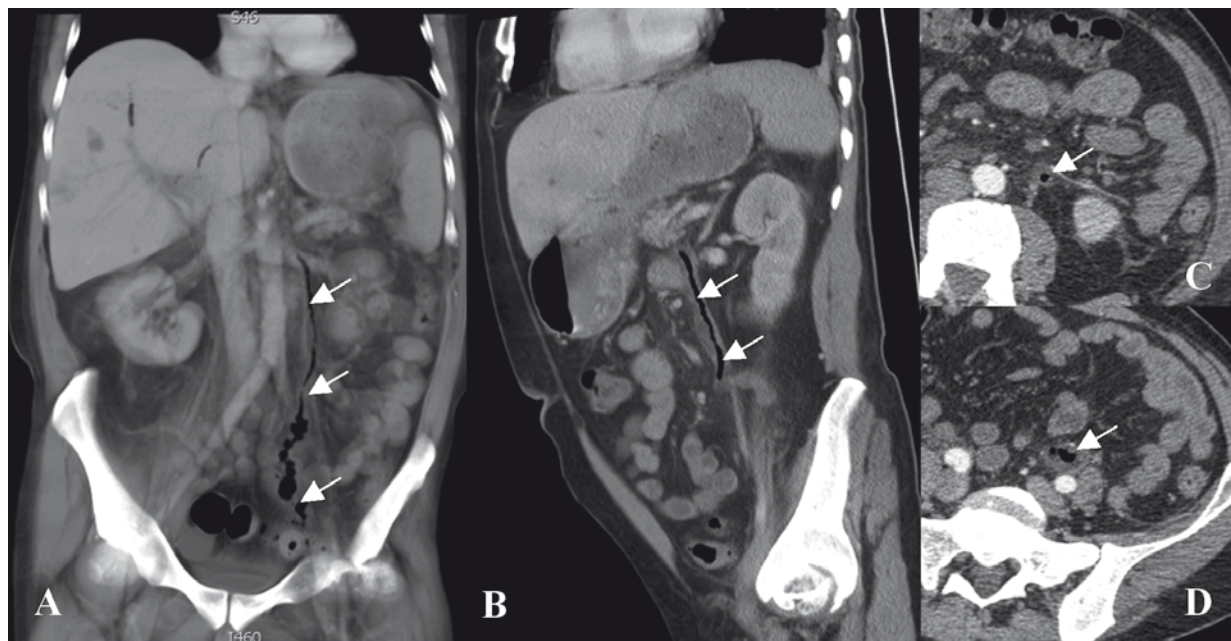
CT reconstructions (A – coronal, B – sagittal, C, D – axial plane, post-contrast series show pathologic air-filled channel with well defined wall, extending from sigmoid colon up to epigastric region. Arterial branches along it's course and anatomical location suggest that inferior mesenteric vein is involved in colovenous fistula
